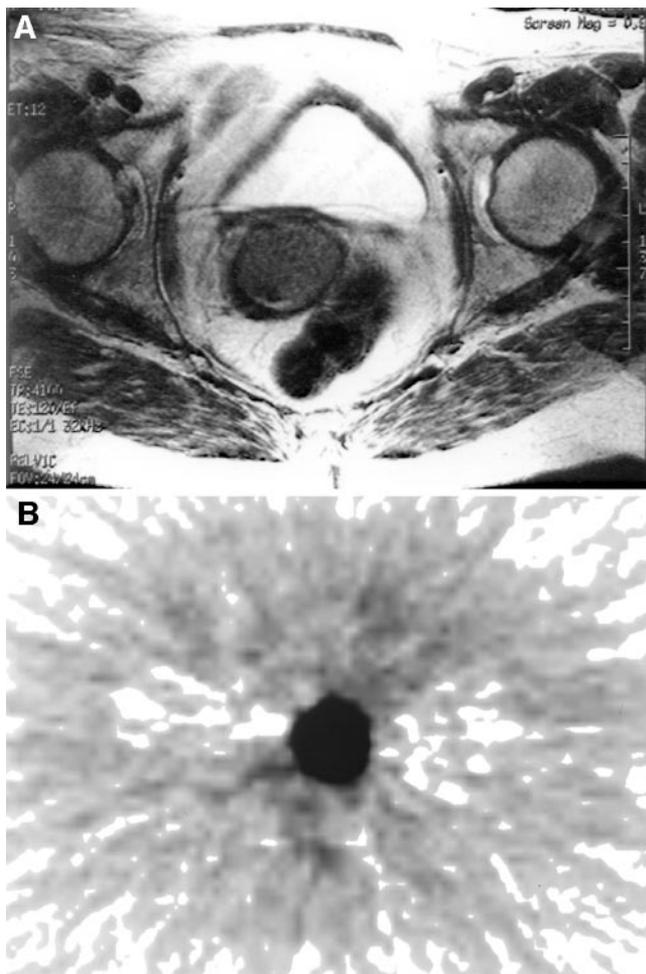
Typical case of malignant cervical cancer (patient 15). Patient was 83-y-old woman who consulted our hospital because of chief complaint of abnormal genital bleeding. (A) MRI revealed mass measuring 3 cm in diameter in cervical region of uterus. (B) ^{18}F -FDG PET images showed marked ^{18}F -FDG accumulation (SUV = 13.58) in region identical to that of mass detected by MRI. Although MRI showed urinary bladder at level similar to that of mass, ^{18}F -FDG in urinary bladder was eliminated by bladder irrigation, which facilitated evaluation of PET images. Diagnosis of squamous cell carcinoma was established on basis of biopsy results.
